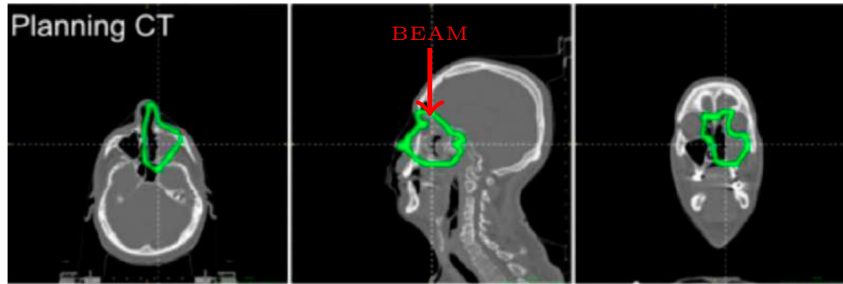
Transverse, sagittal, and coronal views of the CT scan of PZ0. The region where the tumor lesion extends is highlighted in green. In the sagittal view, the beam incidence direction is shown with a red arrow.
